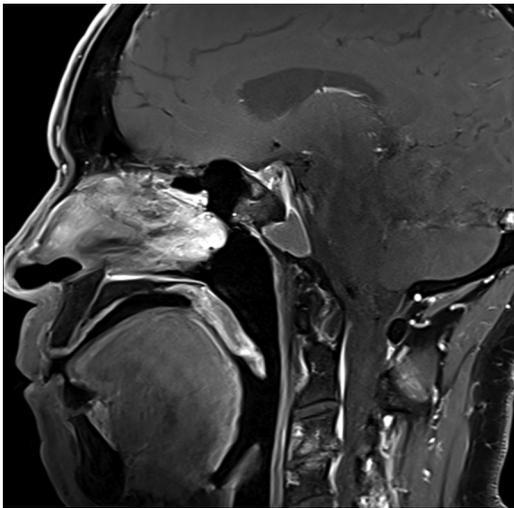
MRI, gadolinium-enhanced T1-weighted sequence, sagittal section, showing an extradural collection over the clivus with peripheral contrast enhancement.
